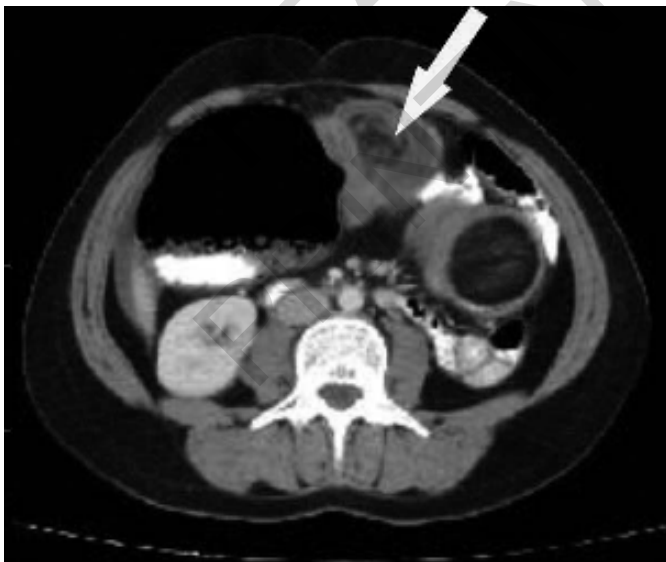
Abdominal CT scan showed a soft-tissue tumor with a fat density of about 6 cm in diameter in the distal part of the transverse colon, and in this area, an intussuscepted colonic segment was detected (white arrow).
